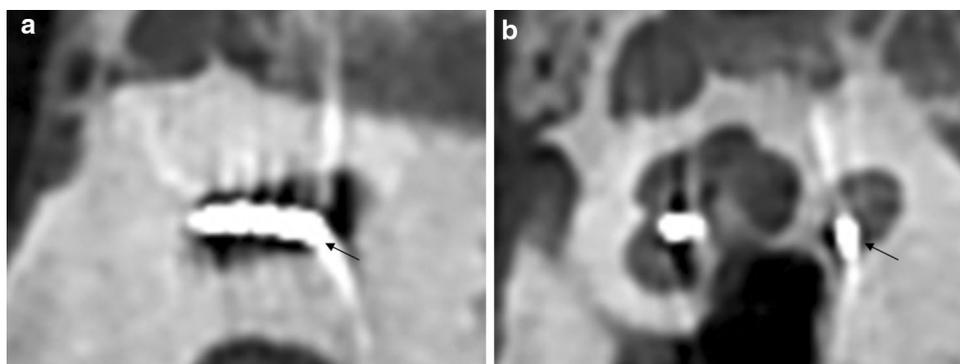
Dislocation on cone beam reconstructions. a Electrode array is moving from inferior part of pars ascendens (scala tympani, *black arrow*) to superior part (scala vestibuli). b Midmodiolar reconstruction showing trajectory modification from inferior part of half-turn
